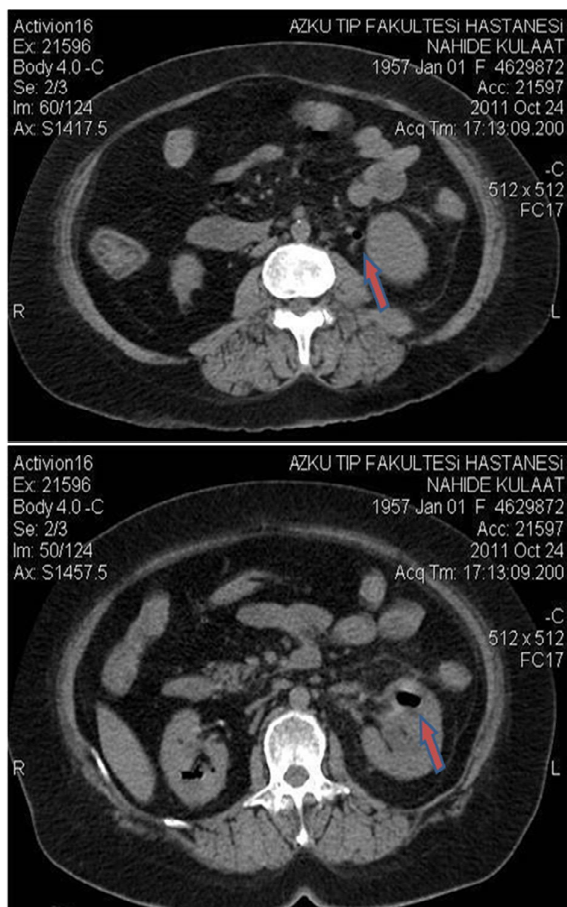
(Upper pannel) Abdomino-pelvic computed tomography scan with air densities in the left ureter
